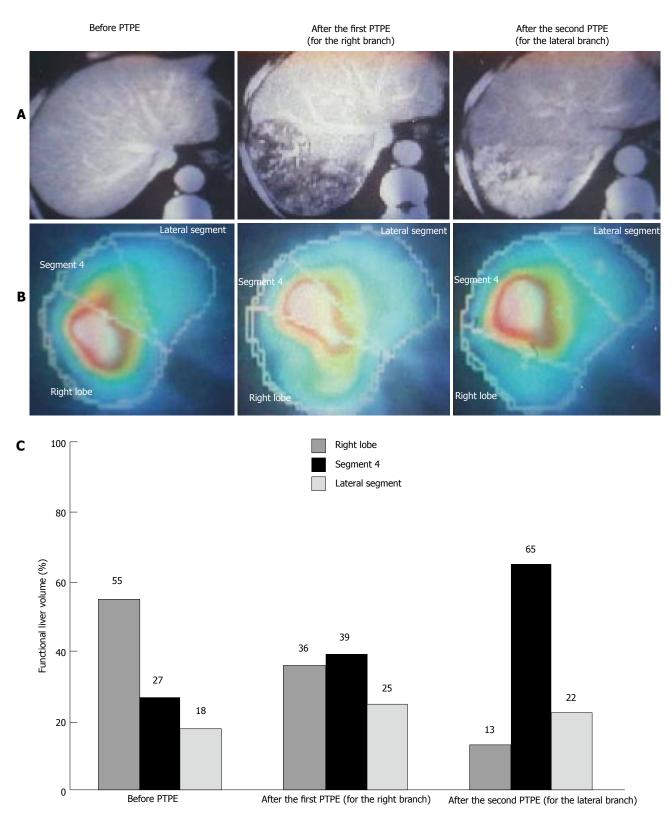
Changes in functional hepatic volume after percutaneous transhepatic portal vein embolization. The angio-computed tomography findings (A), technetium-99m diethylenetriamine pentaacetic acid galactosyl human serum albumin scintigraphy for asialoglycoprotein receptor (B) and the functional hepatic volume (C) were shown in each lobe/segment before and after percutaneous transhepatic portal vein embolization. Functional hepatic volume of each lobe/segment was calculated as a percentage of whole liver volume. PTPE: Percutaneous transhepatic portal.
